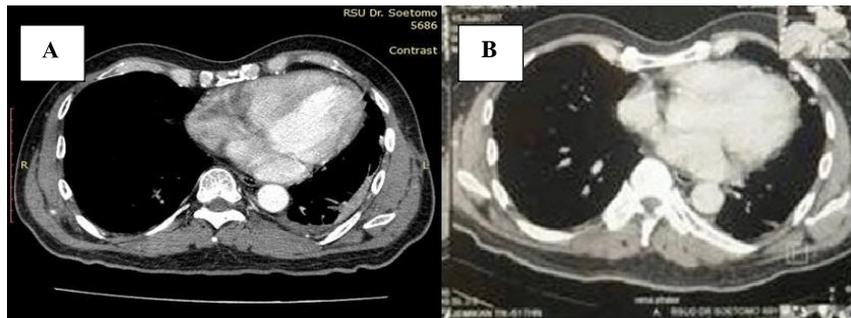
Chest CT scan showed enhanced thickening of the left pleural (64HU) accompanied by fluid density in the pleural cavity caused compressive atelectasis of the inferior lobe and left lung lingula with a suspicious paratracheal lymph node which was leading to mesothelioma, the left pulmonary mass was not revealed.
